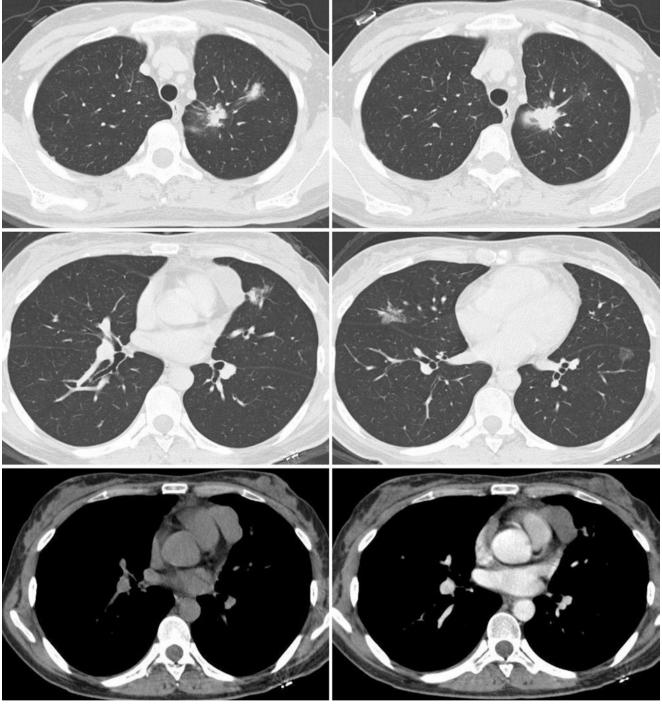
Chest CT images of a 34-year-old woman complained of chest pain for more than 4 months
